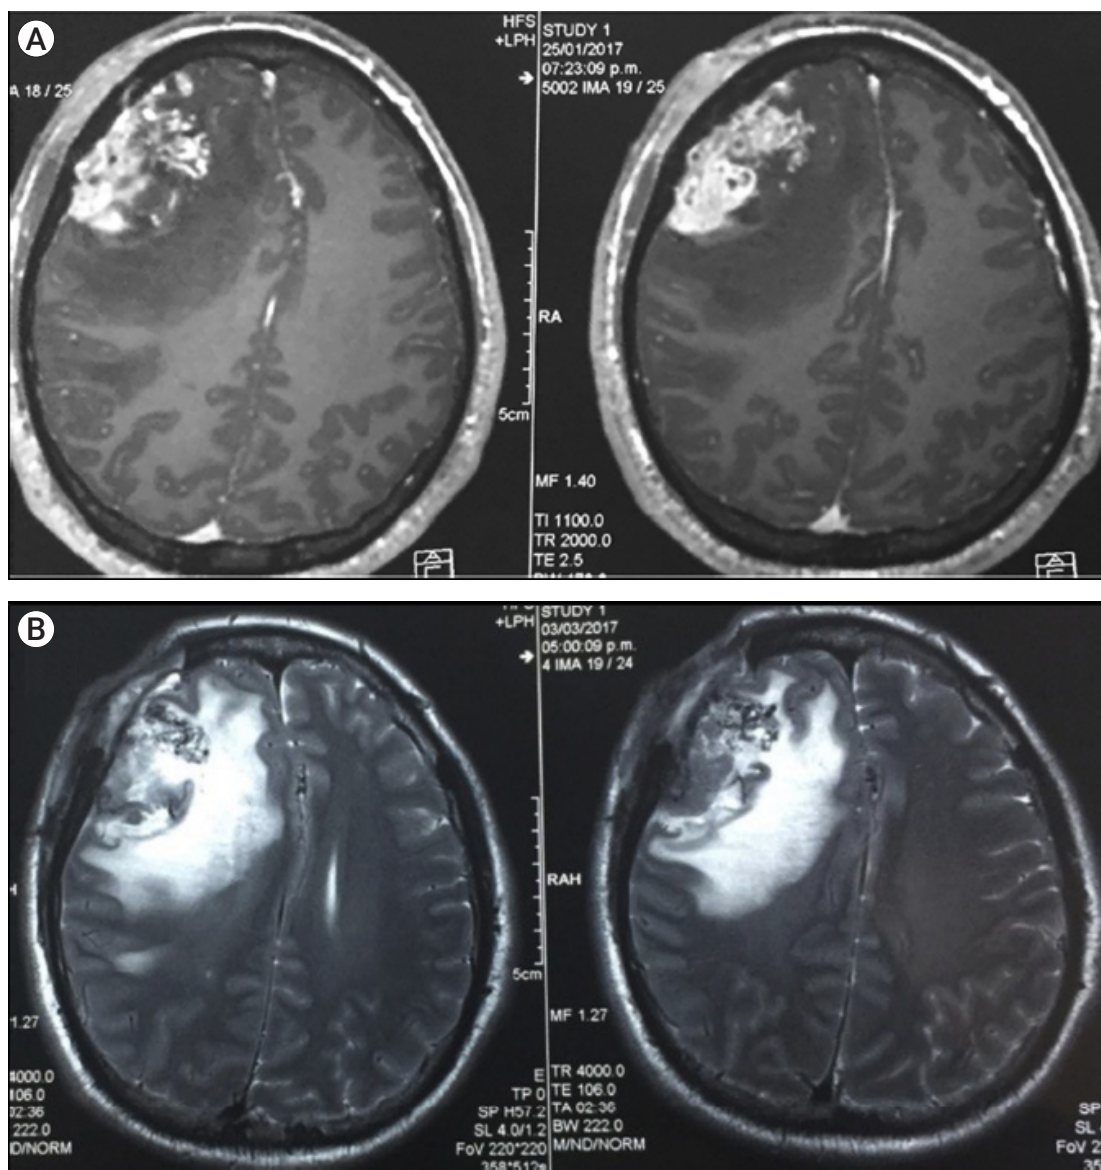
Cerebral T1WI MRI sequences after contrast administration (A) and T2WI MRI sequences (B) revealing a right frontotemporal heterogeneously enhancing expansive lesion with perilesional edema and a residual AVM. MRI, magnetic resonance imaging; AVM, arteriovenous malformation.
